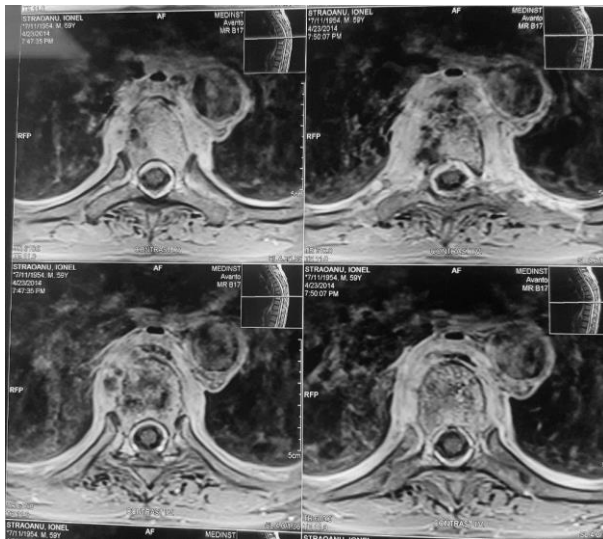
Thoracic MRI with intravenous contrast T2 transverse plane: T7-T8 osteomyelitis with intraspinal abscess (personal collection).
